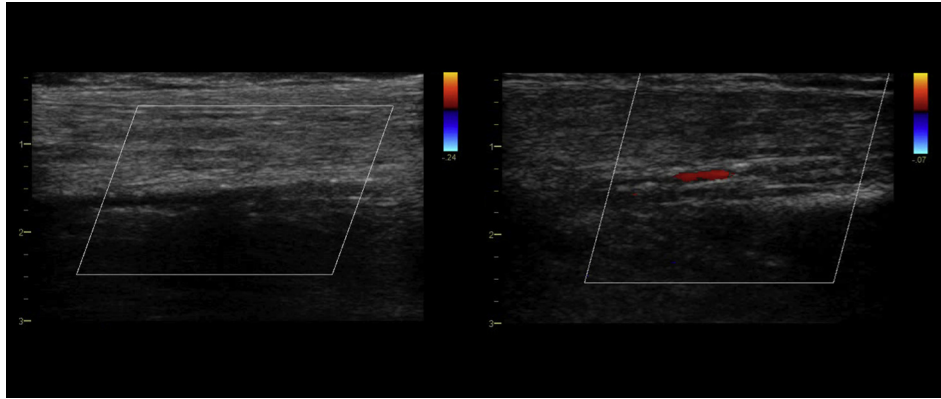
Colour Doppler duplex scan imaging to identify the optimal anastomosis site. Weak flow in a distal artery, especially when there is dense calcification in that artery's walls, cannot be seen with standard colour Doppler duplex scanning in the arterial preset mode (left panel). However, use of the venous preset mode and appropriate slant function provides a colour Doppler signal at the same site (right panel). Detection of such a signal guarantees that the surgeon will be able to incise the arterial wall and easily insert a stitch.
